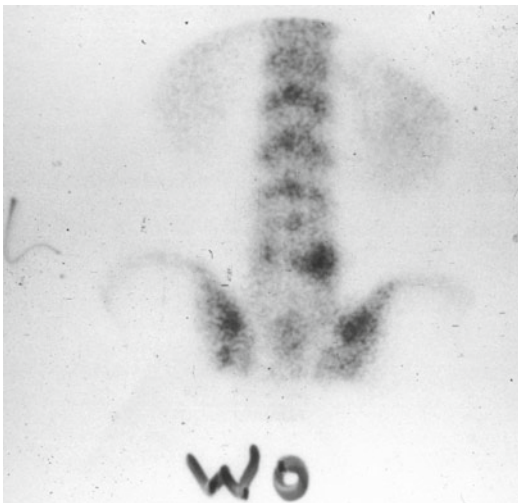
This SPECT scan denotes a focal increase in metabolic activity unilaterally at the L5 region
